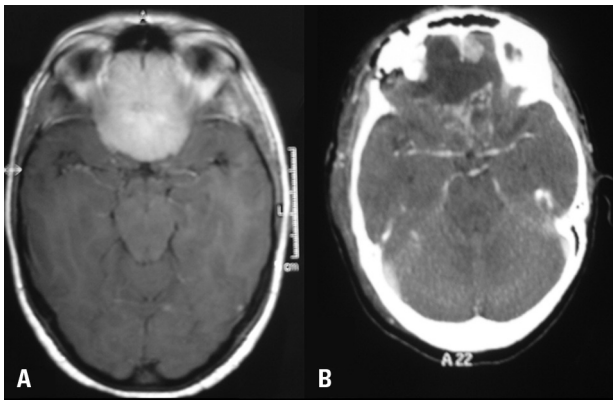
Axial MRI showing an olfactory groove meningioma with anterior extension up to frontal sinus [A]. Post operative CT showing a small remnant on left anterior side [B].
